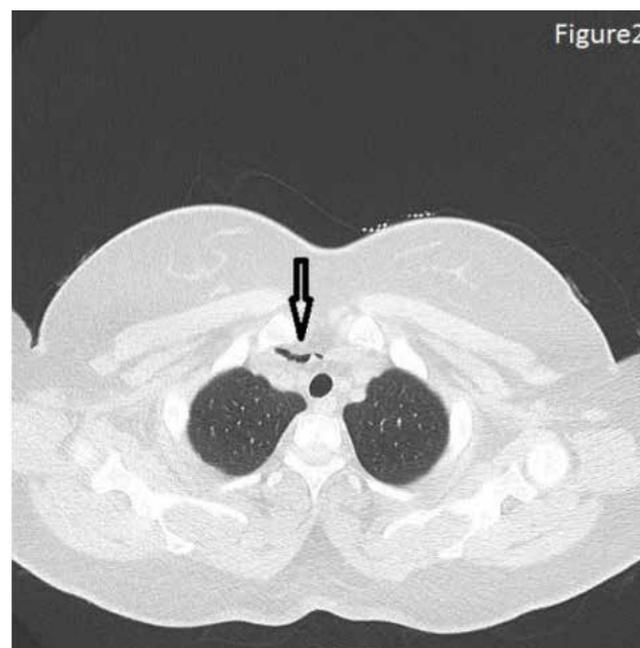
Free air images of the mediastinum in the thorax CT of the patient
